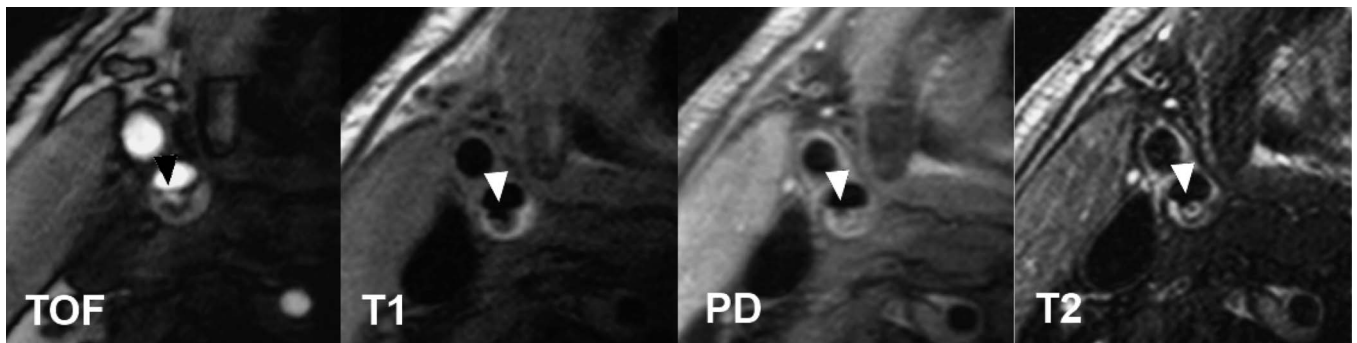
Baseline high-resolution carotid MRI after cryptogenic stroke
